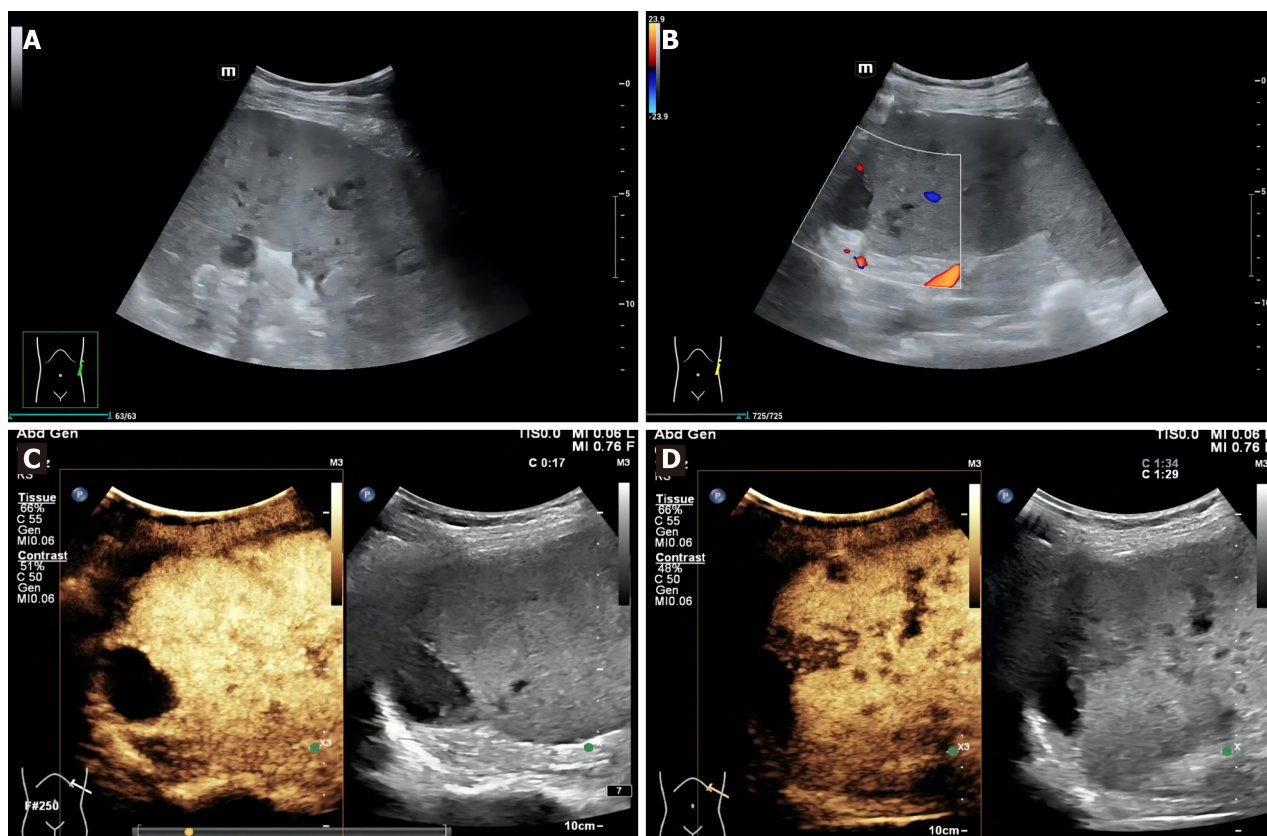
Ultrasonography images of the patient. A: Conventional grayscale ultrasound (US) showed multiple hypoechoic nodules and masses in the spleen; B: There were no blood flow signals in the splenic lesions on Color Doppler US; C: Arterial phase imaging on contrast-enhanced US; D: Venous phase imaging on contrast-enhanced US.
